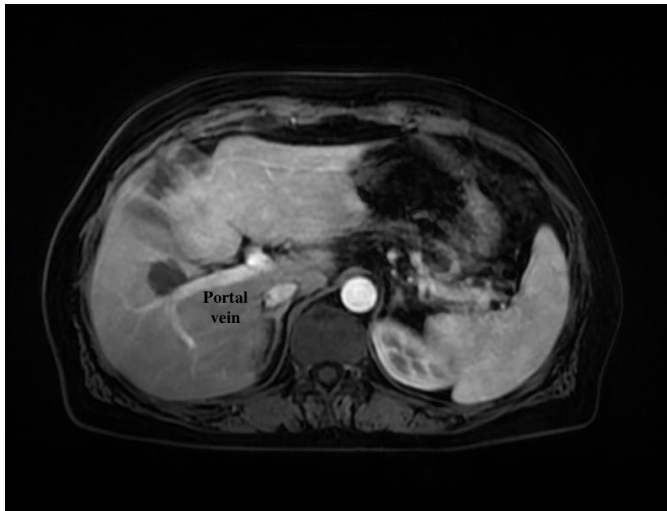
Mass without contrast enhancement in front of the right portal vein on axial MRI after MWA.
